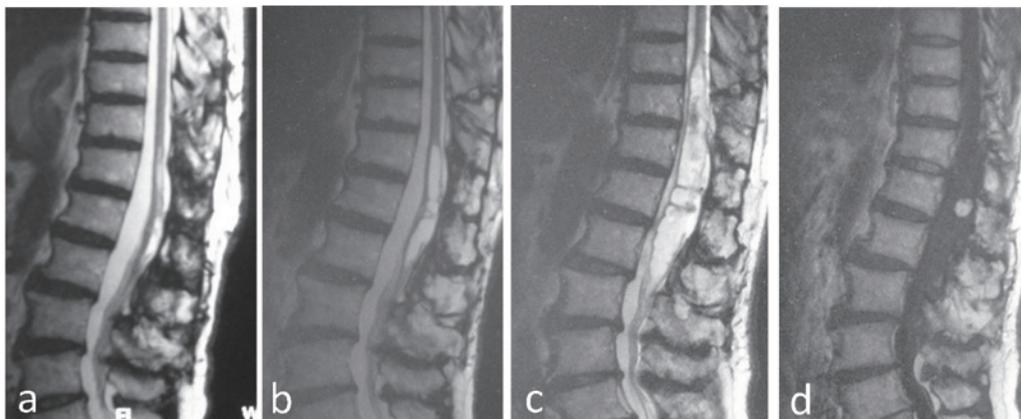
(a) T2 MRI after the first surgery, showing total resection of the tumor. (b) T2 MRI four years after the first surgery, showing regrowth of the tumor. (c) T2 MRI and (d) Gd enhanced MRI nine years after the first surgery.
